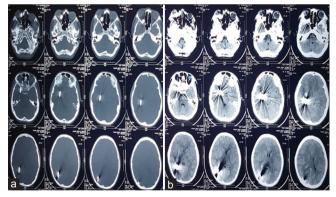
Non-contrast axial computed tomography bone window depicting the arrow's trajectory posteriorly through the right occipital bone (a) and pneumocephalus area with brain contusion (b)
